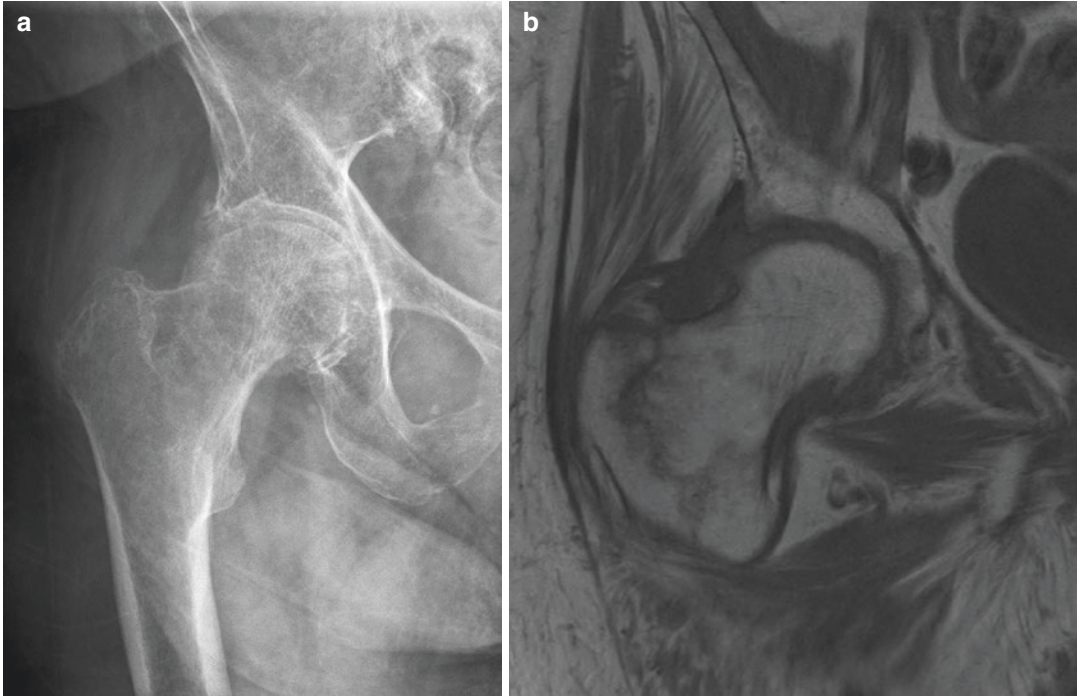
(a) An AP radiograph of the right hip demonstrates degenerative changes with no fracture identified. (b) Coronal slice of T1-weighted MRI demonstrates hypointensity along the intertrochanteric line which confirms the diagnosis of a non-displaced, standard obliquity, intertrochanteric femur fracture
